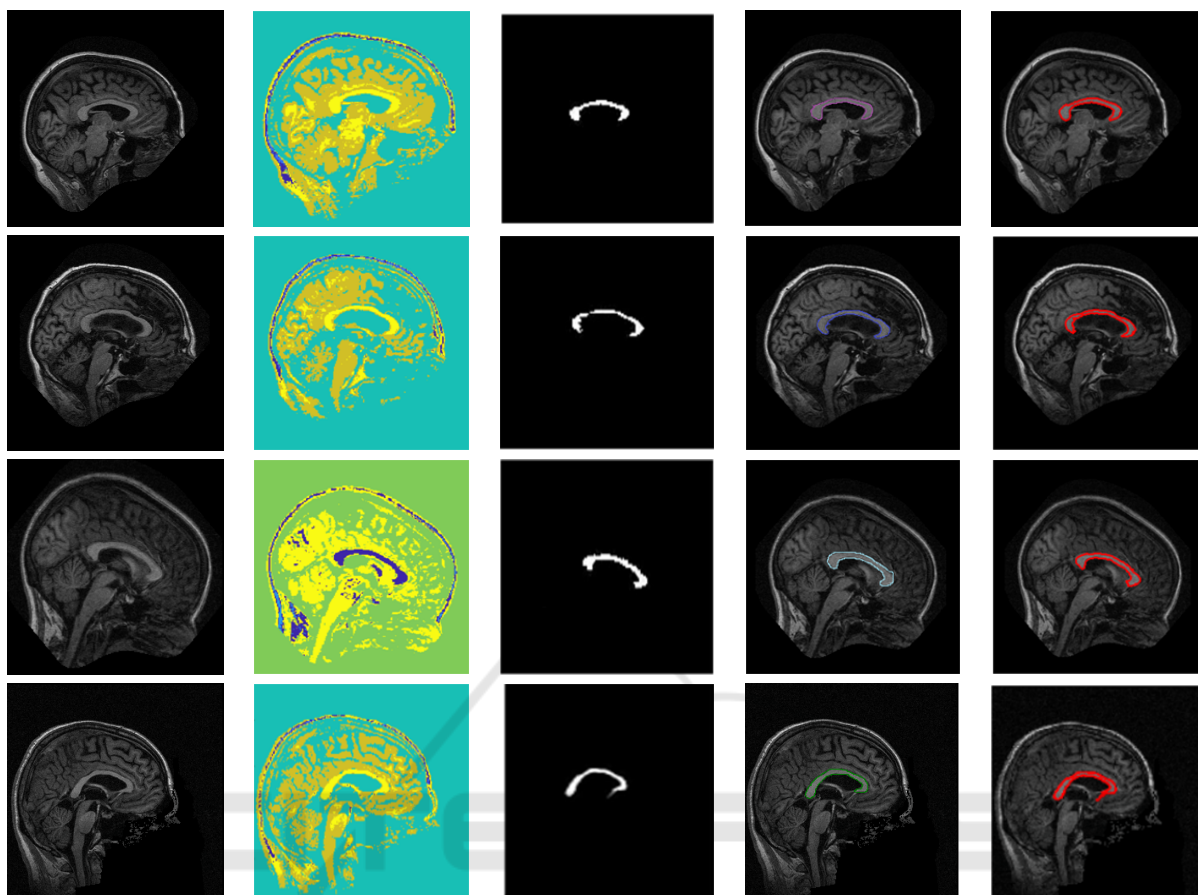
Qualitative evaluation: (a) Input image. (b) Cluster Map. (c) Isolated CC. (d) Ground-truth (e) Delineation of the CC by the proposed method (except the last two MRI scans, where C^* is equal to 4, C^* is equal to 5 for the remaining scans).
